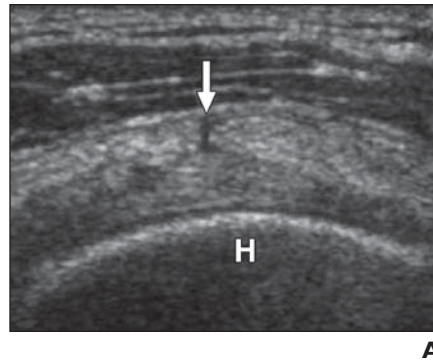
21-year-old woman, a Division 1 college tennis player with shoulder pain for 1 year. MR arthrogram revealed SLAP (superior labrum anterior to posterior) lesion that was not confirmed at arthroscopy. Capsulorrhaphy was performed with no relief in symptoms. Repeat shoulder MRI was negative. A, Short-axis sonogram of supraspinatus tendon reveals linear hypoechoic focus at bursal surface of tendon (arrow). H = humeral head. B, Short-axis sonogram of supraspinatus tendon after 5 mL of 0.5% bupivacaine was instilled percutaneously under sonographic guidance into subdeltoid space shows fluid entering bursal-sided supraspinatus tear (asterisk).
